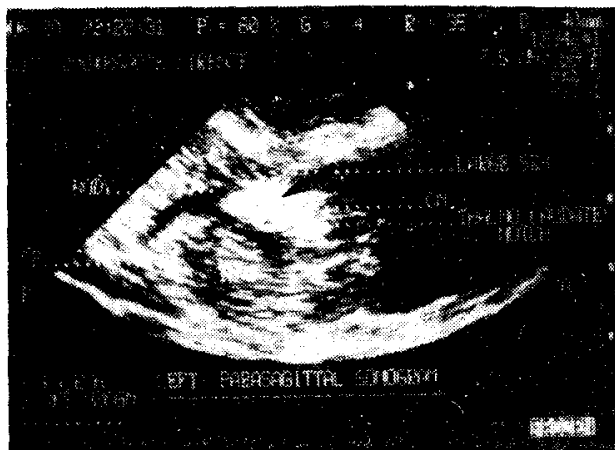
Para-sagittal sonogram (left) showing subependymal hemorrhage (arrow) in the region of caudate nucleus (CN).
